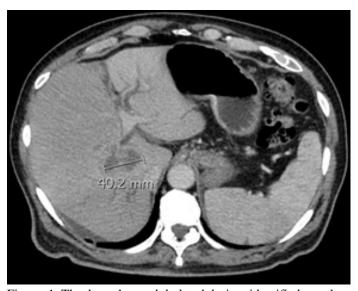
The hypodense, lobulated lesion identified on the initial CT scan which measures up to 4 cm. The intrahepatic biliary duct dilation and portal vein thrombosis were also identified on this scan but not seen on this slice.
